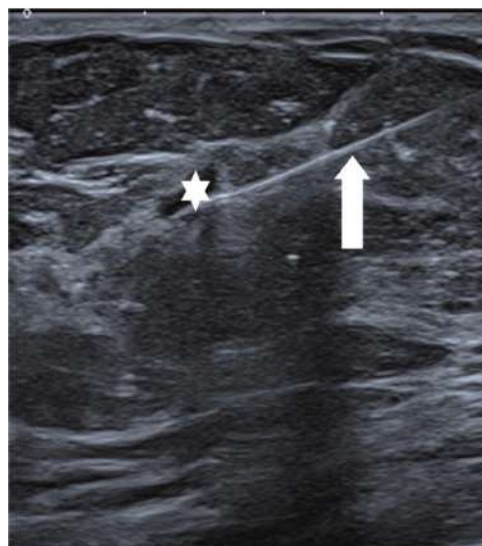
Ultrasound-Guided Core Needle Biopsy of a Breast Lesion
